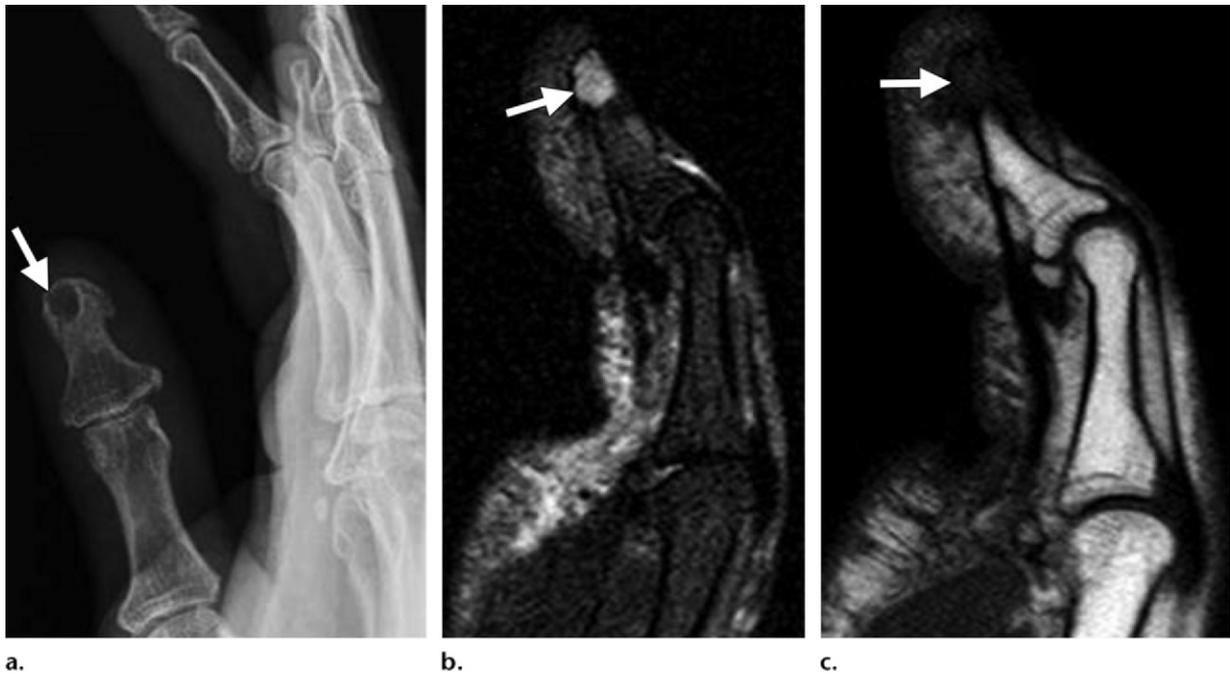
Glomus tumor mimicking a primary bone lesion. (a) Lateral radiograph demonstrates a lucent lesion in the tuft of the first digit (arrow). (b, c) Sagittal fat-saturated T2-weighted (b) and T1-weighted (c) MR images shown the lesion with high and low signal intensity, respectively (arrow), findings that are typical of glomus tumor. Gadolinium-enhanced imaging demonstrated avid enhancement. Pathologic analysis revealed a glomus tumor.
